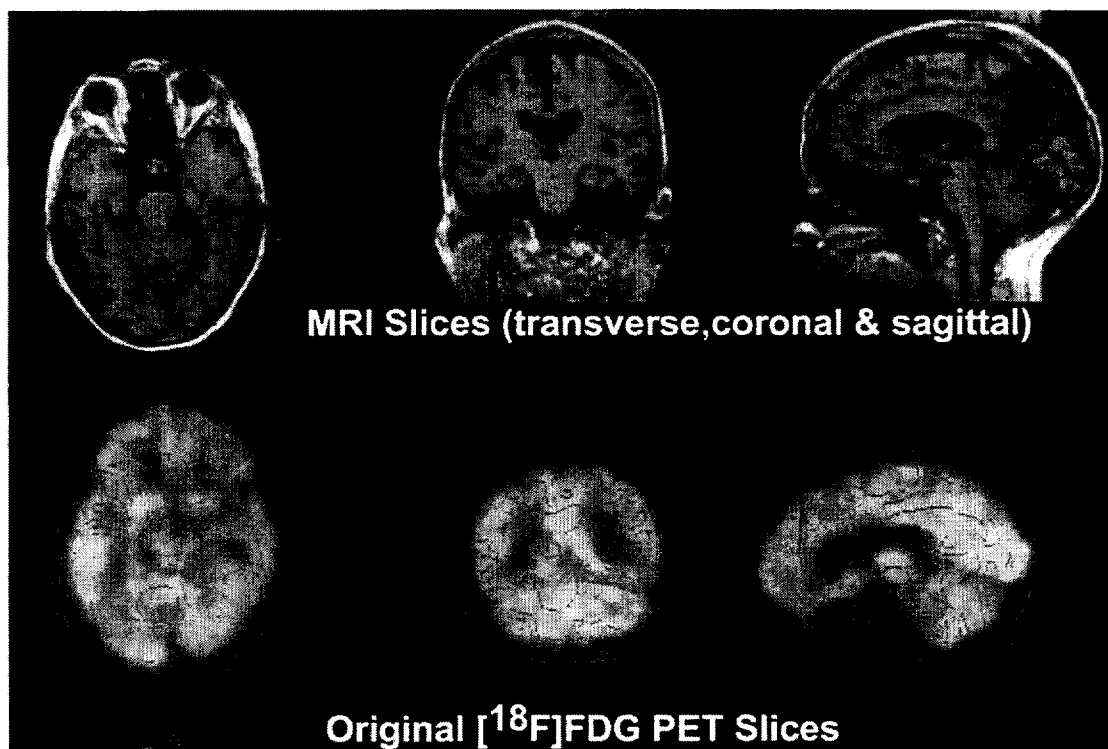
Manual Segmentation. FDG PET data are quickly registered to the MRI dataset using this manual interface. The registered PET data are thresholded and used as a binary mask to automatically segment the brain from non-brain structures in the MRI. Once the segmentation is obtained, the registration is refined using automated techniques.
